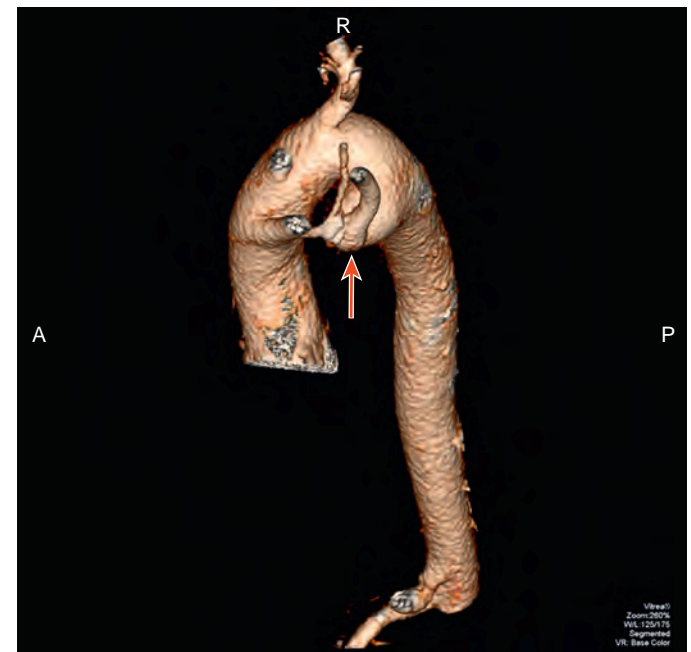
Three-dimensional computed tomographic angiogram from the left lateral perspective of the same patient. The patient has a right-sided aortic arch. The trachea is compressed by the ring formed by the aberrant take-off of the left subclavian artery and the Kommerell diverticulum, which forms the origin of the left common carotid (arrow).
